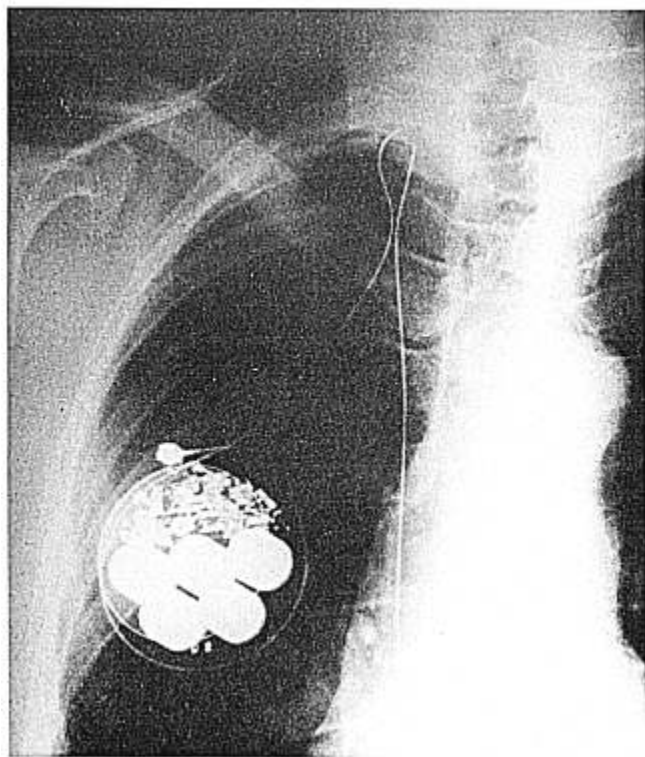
This X-ray reveals a broken lead located at the acute turn above the clavicle. It is easy to miss a lead fracture such as this one when the patient has a heart rate greater than the pacemaker rate and has a VVI generator. (Reprinted from Mansour MK: Complications of cardiac pacemakers. *Am Surg* 4:132, 1977, with permission of author and publisher.)
